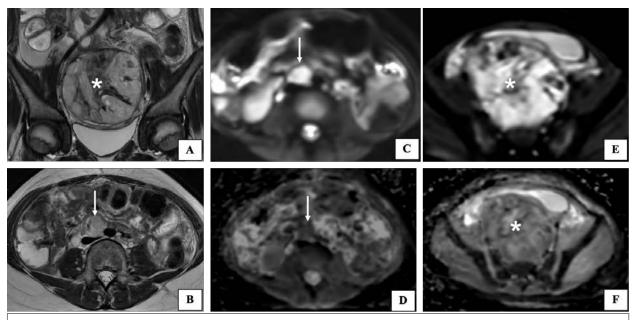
MRI Coronal T2 (A), axial T2 (B), axial DWI (C and E) and axial ADC (D and F) images show a heterogeneous solid lesion (asterisk) in the pelvis appearing hyperintense on T2 with internal hypointense fibrous septae and demonstrating restricted diffusion. An enlarged necrotic paraaortic lymph node (white arrow) is also noted with diffusion restriction.
